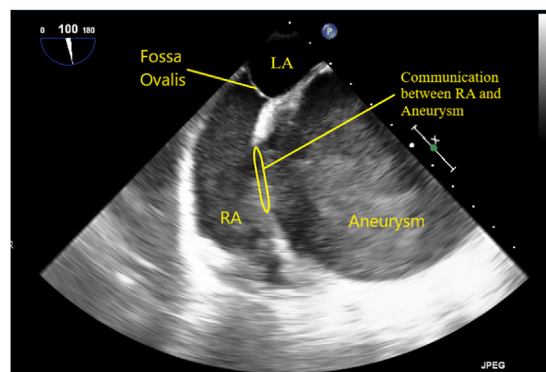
Preoperative transesophageal echocardiogram demonstrating large coronary artery aneurysm with communication into the RA. LA, left atrium; RA, right atrium
